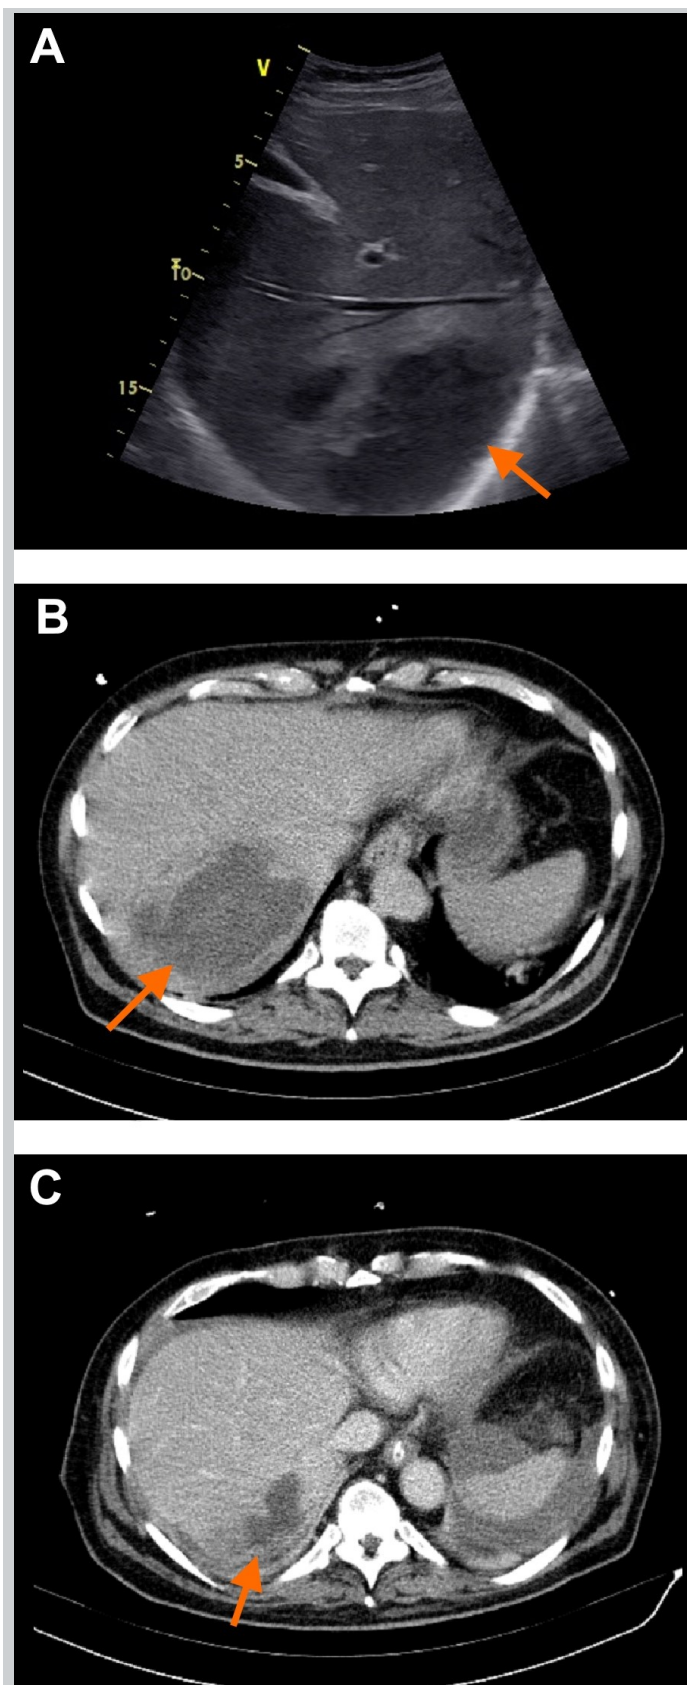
Abdominal point-of-care ultrasound showing an heterogeneous liver lesion (1A, arrow), confirmed as a liver abscess in the contrast-enhanced abdominal computed tomography (1B, arrow). There was significant decrease of the abscess after two weeks of therapy (1C, arrow).
